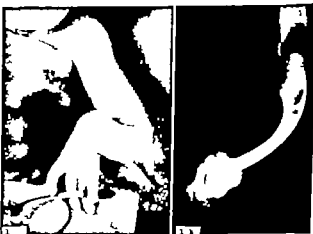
Typical severe deformity due to congenital absence of radius in a four-year-old boy. a The hand is pronated about the bent ulna and extension is limited. b X-ray of the hand and forearm shown in a.
